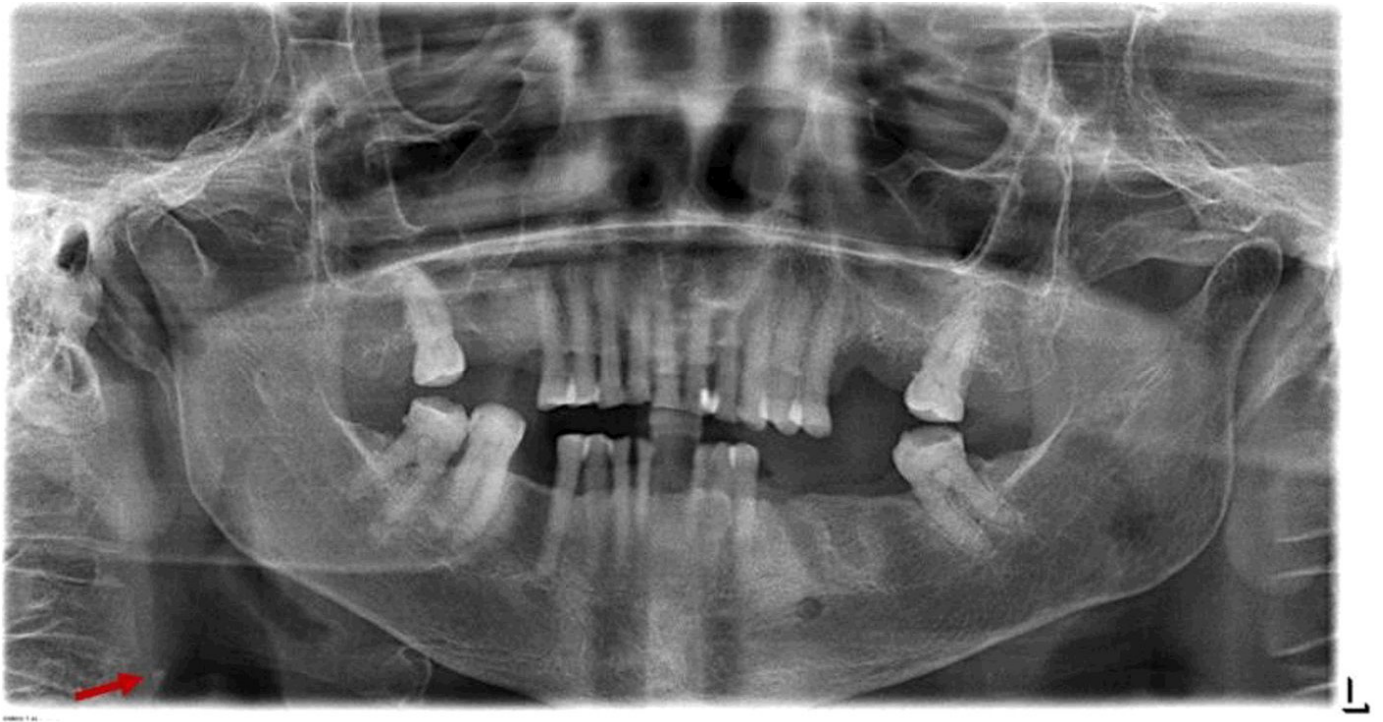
Unilateral single carotid artery calcification (CAC) on the right side of panoramic radiograph.
